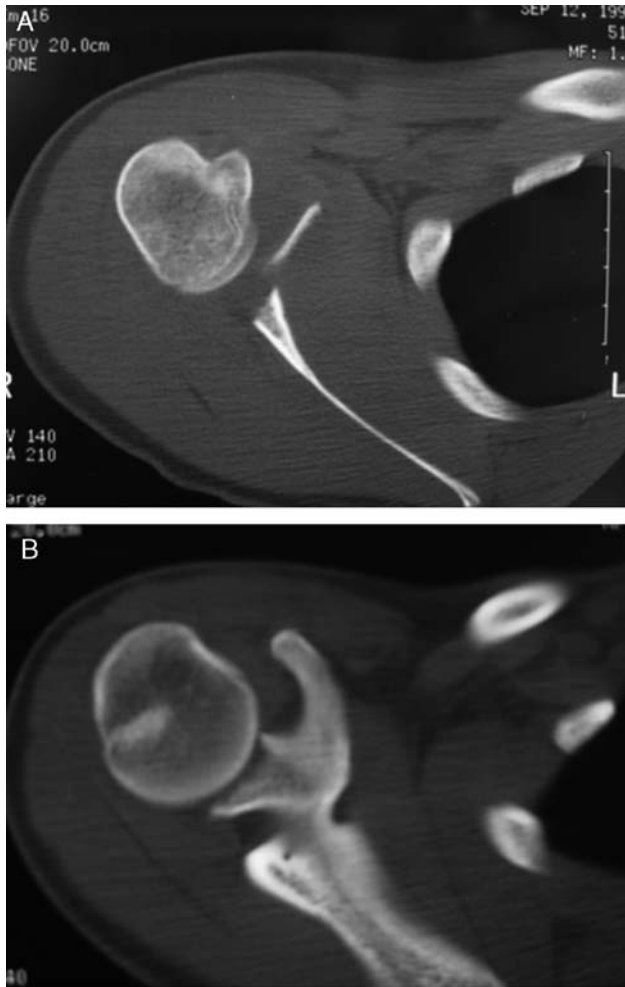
A and B, Shoulder CT scan showing a fracture with complete anterior dislocation of the glenoid fossa. The humeral head sits in its normal position.
